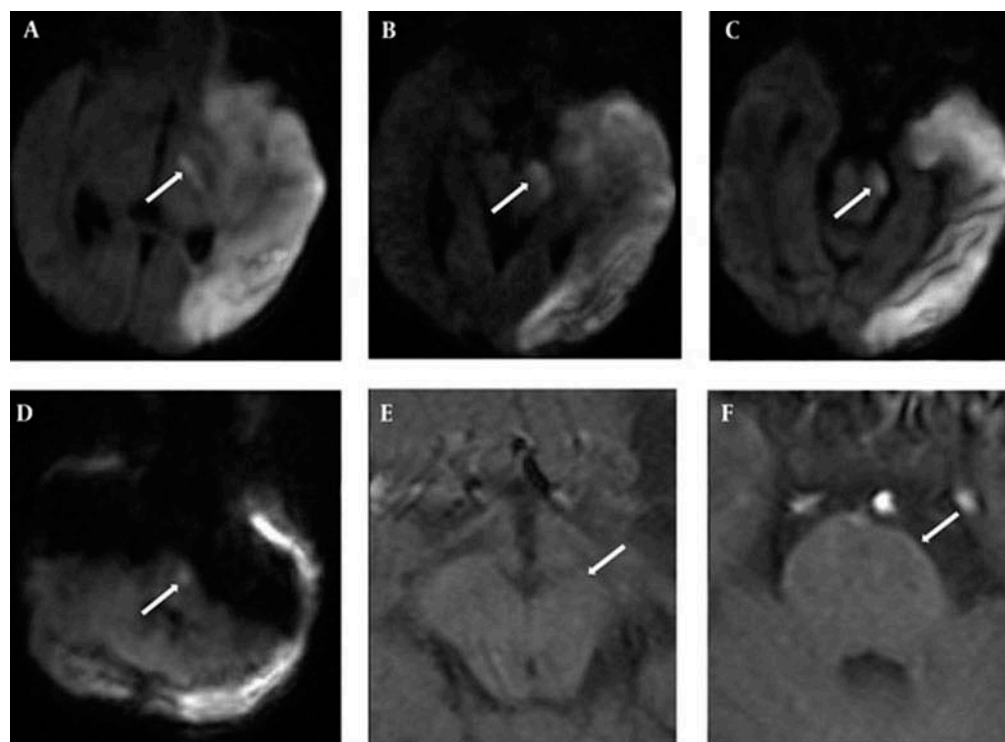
DWI findings on day 5 of life with DSCT Pre-wallerian degeneration over the PLIC (a), Peduncle (b, c), and basis pontis (d). T1WI performed when the infant was 8 months of age showed volume loss over the left cerebral peduncle (e) and basis pontis (f), compatible with Wallerian degeneration (arrow).
